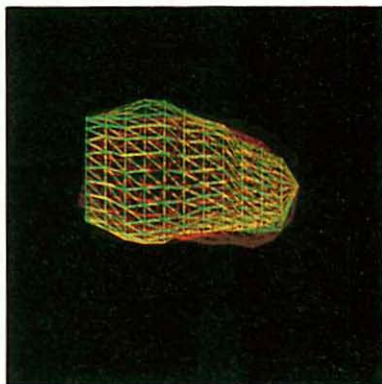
Relationship between SPECT and MR LV surfaces after registration.
